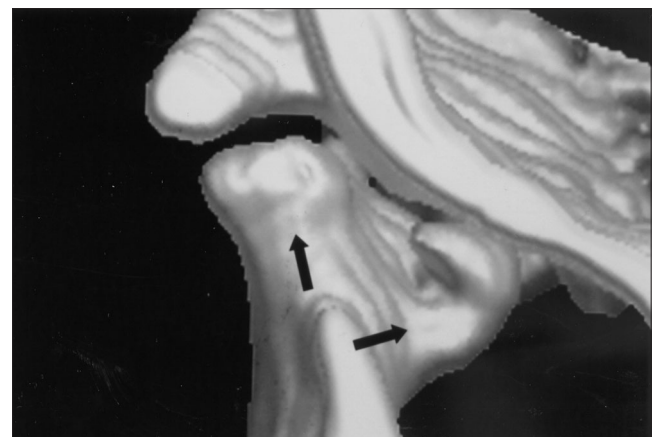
Three-dimensional reconstruction based on helical computed tomography (performed at the 4-year follow-up) indicates the presence of a bifid mandibular condyle. The medial (left) and lateral (right) condylar heads are evident.
